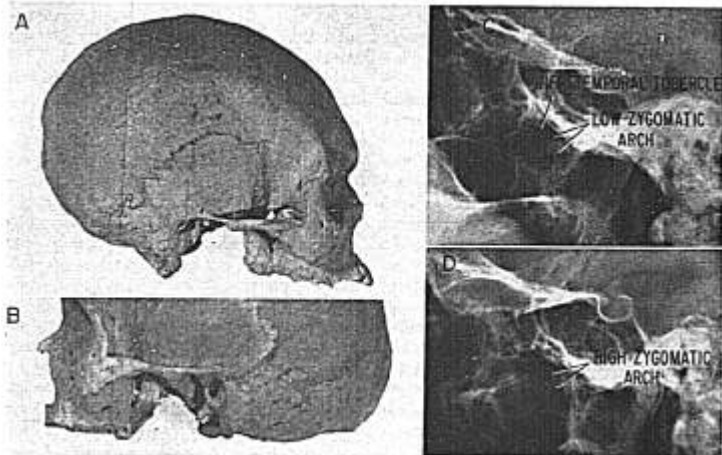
Photograph of two skulls. One (A) with a low and second (B) with a high zygomatic arch. In the first the pterygomaxillary fissure extends considerably above the arch. The skulls are in sagittal and horizontal position. Radiograph (C) showing low zygomatic arch and (D) showing a high zygomatic arch.
